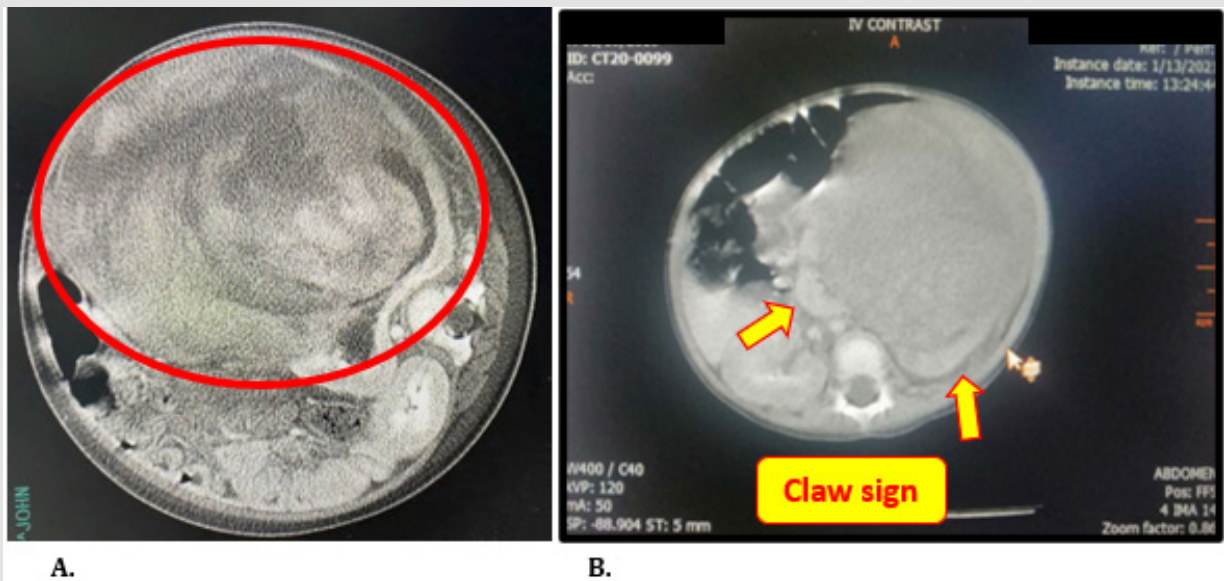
Computed Tomography Scan of the abdomen with contrast:
